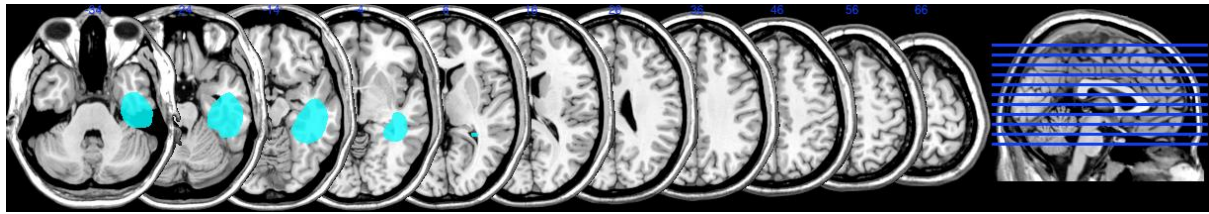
MRI scan of patient AEK
